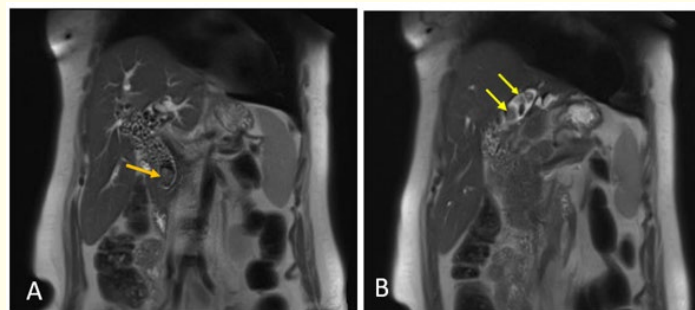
Coronal sections of a Bili-MRI in T2 HASTE sequence, (A): impaction of lithiasis in the common bile duct (CBD) above a large stone (orange arrow), with significant enlargement of the CBD. (B): showing dilated bile ducts with multiple intraductal gallstones (yellow arrows).
